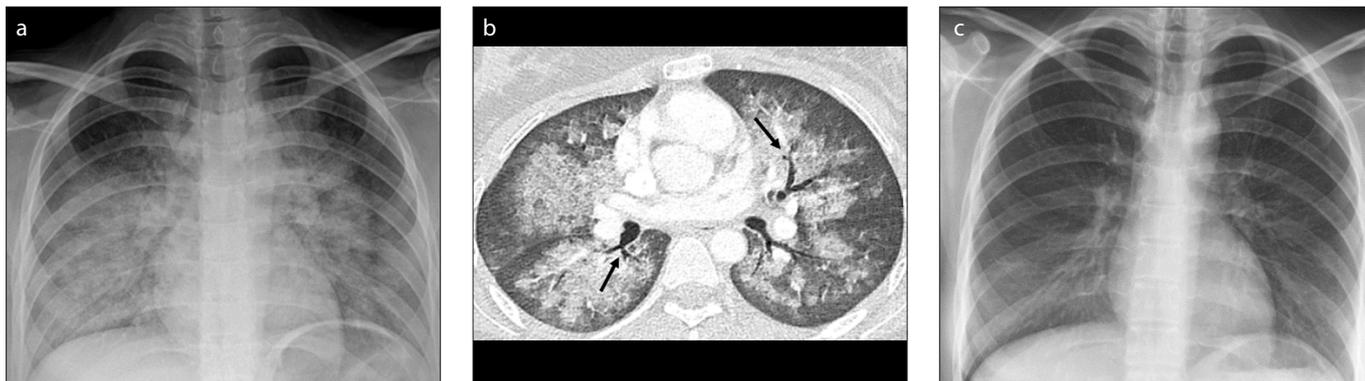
a–c. A 30-year-old woman with a history of melanoma undergoing HDIL-2 therapy presented with dyspnea. Chest radiograph (a) shows bilateral diffuse air-space opacities. Bilateral costophrenic angles are spared. Axial chest CT image (b) demonstrates bilateral ground-glass opacities and air bronchograms (arrows). The heart is normal in size. The findings were consistent with HDIL-2 induced pulmonary edema. HDIL-2 therapy was stopped. Chest radiograph obtained two weeks later (c) reveals the resolution of findings.
